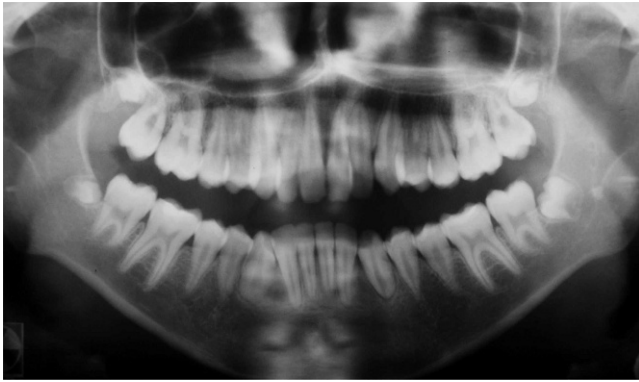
Panoramic radiograph of a 6-year-old patient at diagnosis who was submitted to chemotherapy and 6,750 cGy irradiation. Note blunted and shortened V-shaped roots of the upper and lower premolars and second molars.
